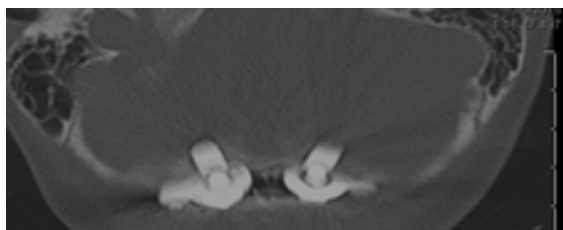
Non-contrast axial CT of the head with post-operative placement and fixation of the bolt/nut construct.
